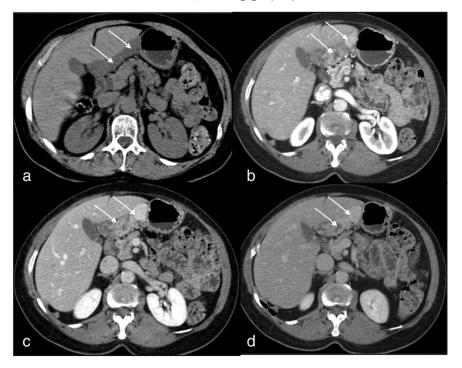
CT examination. The axial images acquired before (a) and after iv administration of the contrast medium—respectively in arterial (b), portal (c), and delay (d) phases—show a large mass (arrows) along the inferior margin of the left hepatic lobe, characterized by a slowly progressive filling, without any necrotic or hemorrhagic areas.
